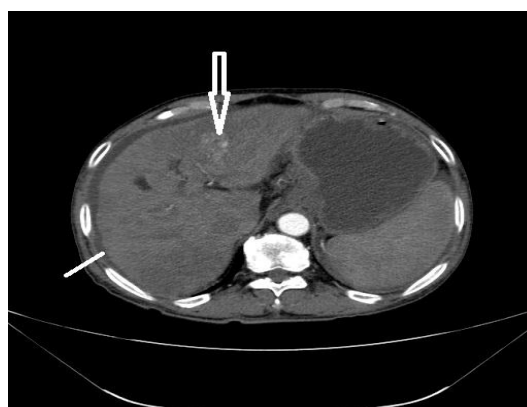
Axial contrast enhanced arterial phase computed tomography showing irregular liver margins (arrow) & an illdefined hyperenhancing lesion in the left lobe of liver (arrowhead)
